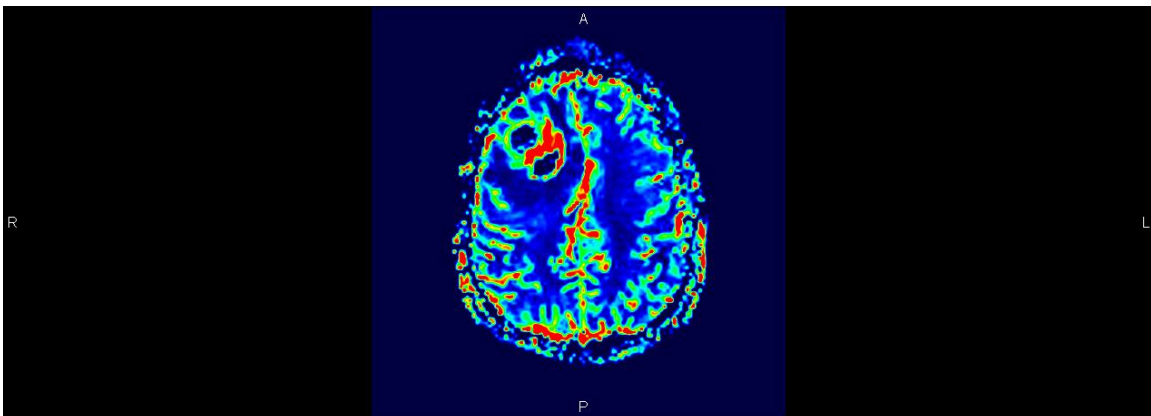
Axial DSWP (Dynamic Susceptibility-Weighted Perfusion) MRI. (rCBV map). Area of increasing rCBV in the periphery of the lesion corresponding to the rim of enhancement on the post-gadolinium image.
